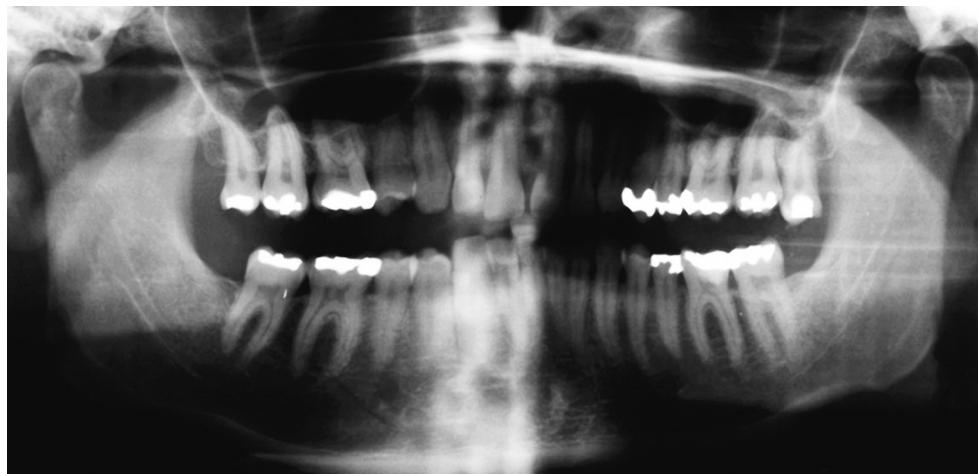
Plain x-rays, such as panoramic x-rays, are the minimum standard for preoperative evaluation.
